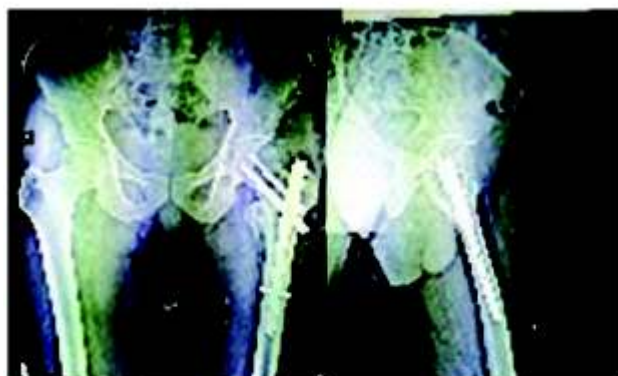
Showing Postoperative x-rays
